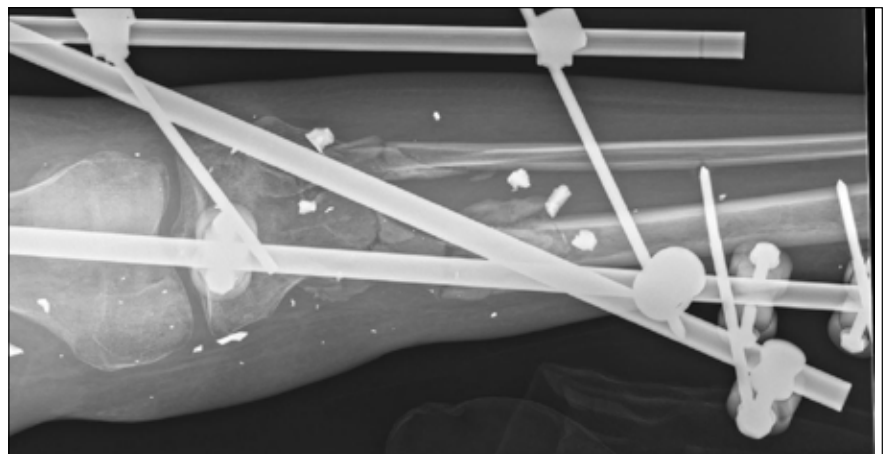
The a.p. radiograph of the right lower leg of the same patient showing multiple foreign fragments
